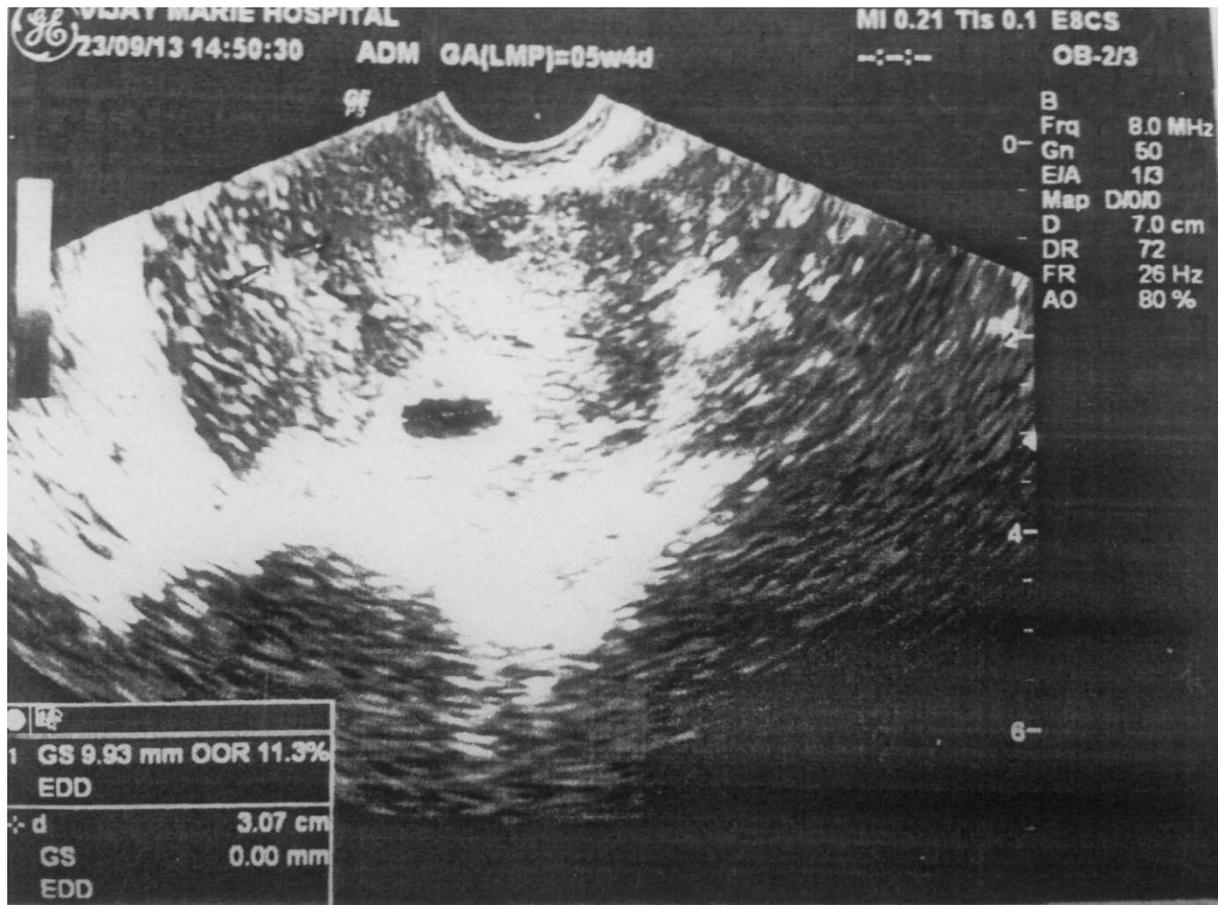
Ultrasound of pelvis
